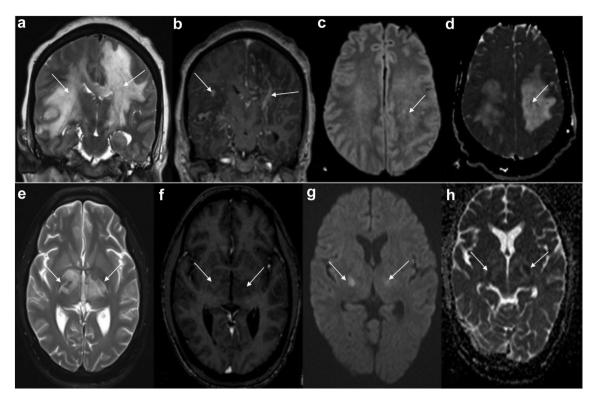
(a-d): MRI T2 weighted coronal imaging showing 'tunnel-sign', involvement of white matter tracts causing cerebritis, (e-h): MRI showing typical progression along the corticospinal tracts, with involvement of posterior limb of internal capsule and ascent along the fibres, causing cerebritis.
